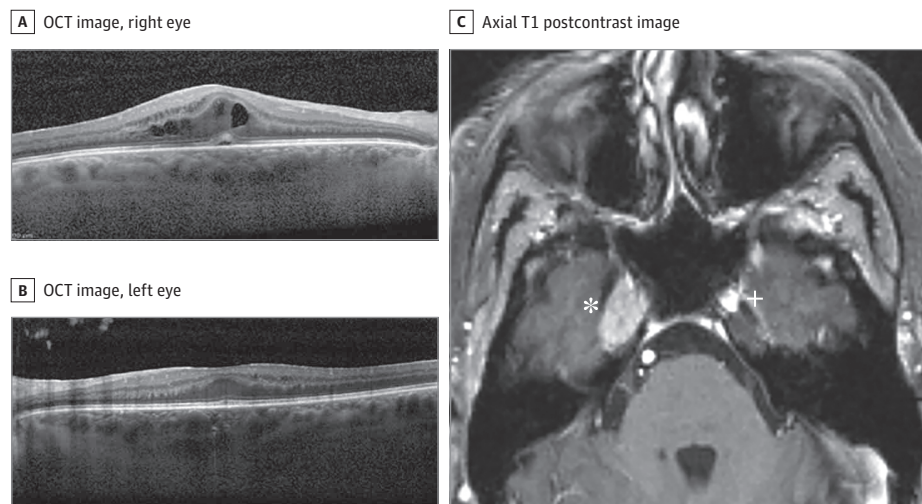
A, Optical coherence tomography (OCT) image showing the right eye had cystoid spaces in the inner nuclear, outer plexiform, and outer nuclear layers. B, OCT image showing that the left eye had trace cystoid spaces in the inner nuclear layer. C, Axial T1 postcontrast magnetic resonance image showing an enhancing mass filling and expanding the Meckel cave (asterisk). The other, normal, fluid-filled Meckel cave is noted for comparison (plus sign).
